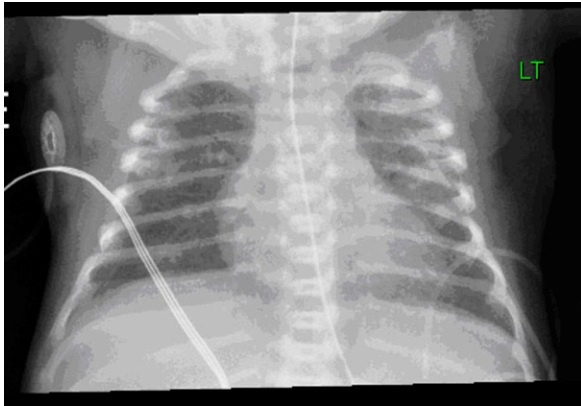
Chest radiograph of anteroposterior view demonstrating bilateral patchy opacities consistent with syphilitic pneumonitis.
